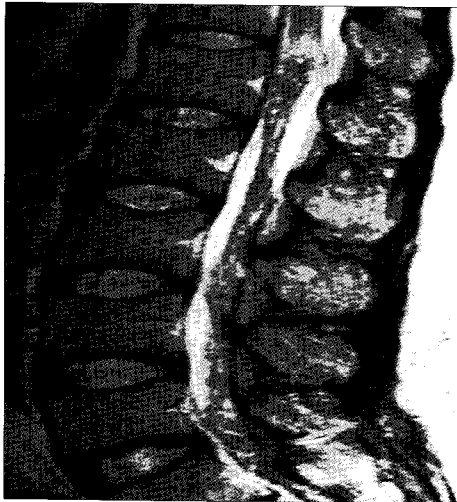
The preoperative MRI of case 1. T2-weighted magnetic resonance (MR) image shows a nodular-shaped mass (15×10 mm) in the conus medullaris and severe inflammation and adhesion of the cauda equina.
